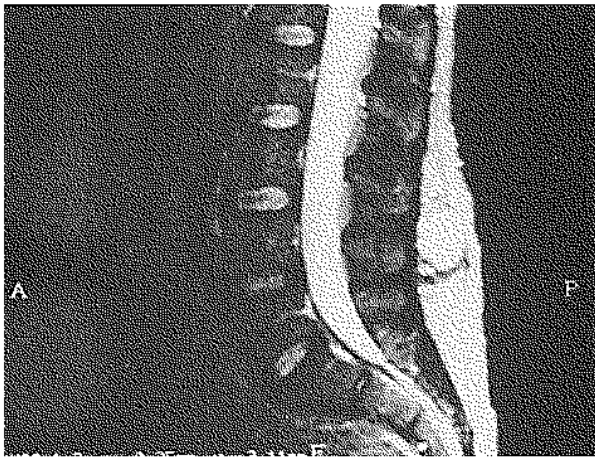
On this T2-weighted image the mass shows a significant increase in signal intensity, and the daughter cysts are isointense with the matrix.
